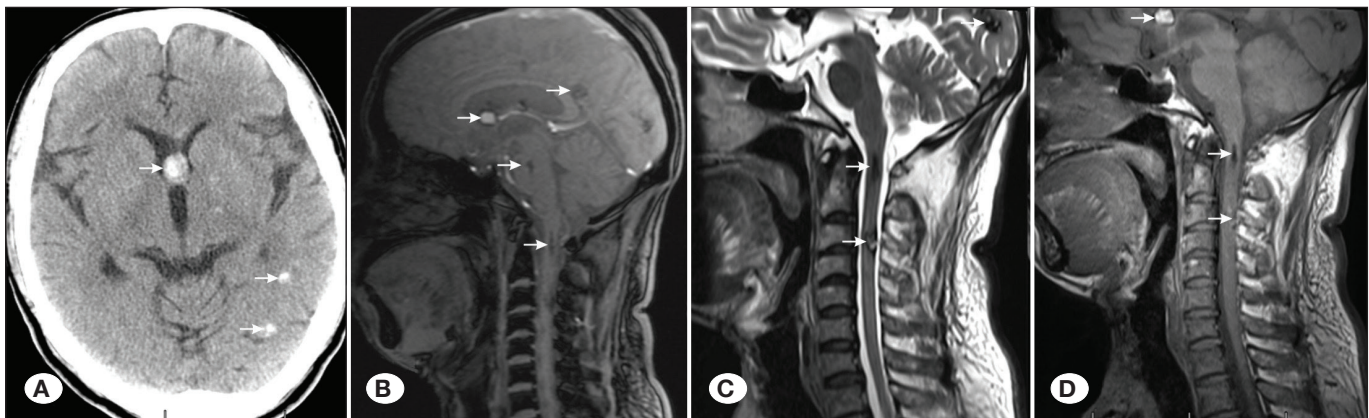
Intramedullary disseminated cysticercosis. A) CT image of intracranial lesions (arrows), B) T1-weighted MR image of intramedullary dissemination (arrows), C) T2-weighted MR image of intramedullary dissemination (arrows), D) No obvious enhancement on enhanced MRI (arrows).
